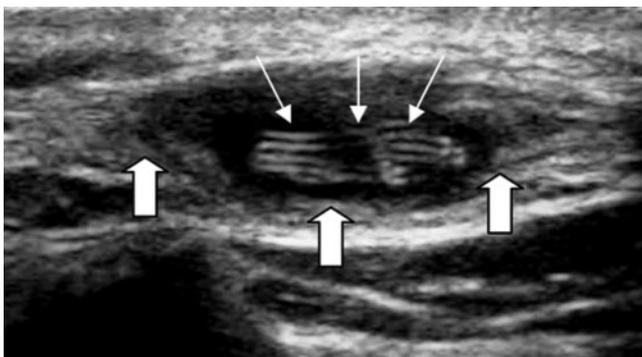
Greyscale sonogram showing a thick-walled, hypoechoic, subcutaneous cystic lesion (large arrows) with multiple linear echogenic structures (small arrows). These linear structures showed persistent twirling motion on real-time imaging.
